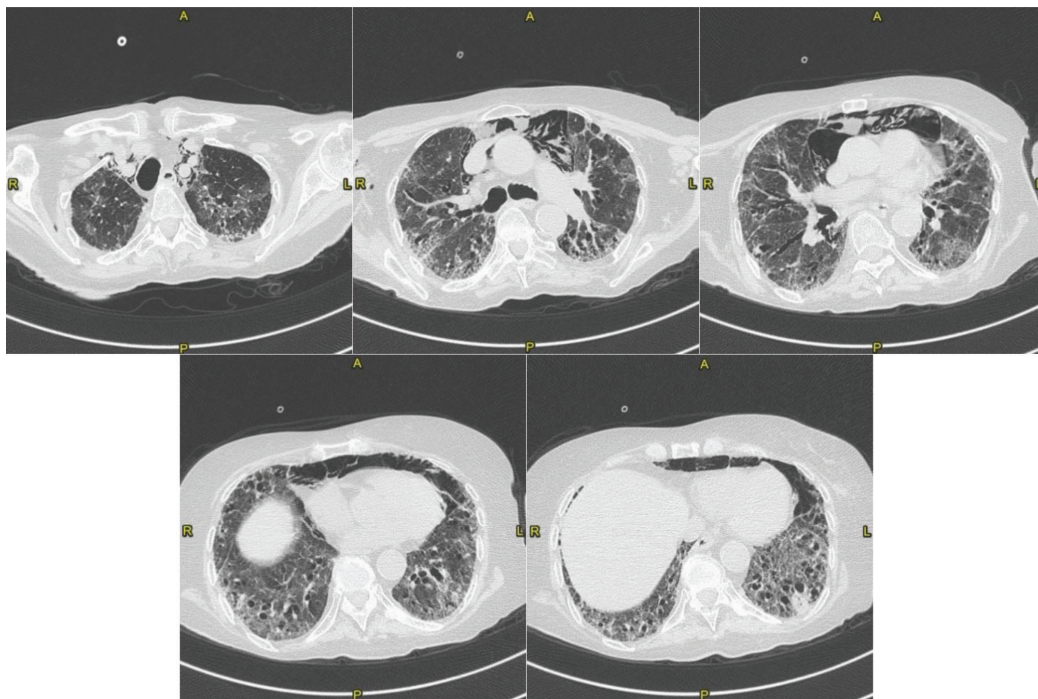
CT scan after 5 weeks since admission (October 2020): The parenchymal fibrosing pattern is unchanged. The known parenchymal peribronchial consolidation of the inferior left lobe is also unchanged. Significant increased the known pneumomediastinum.
